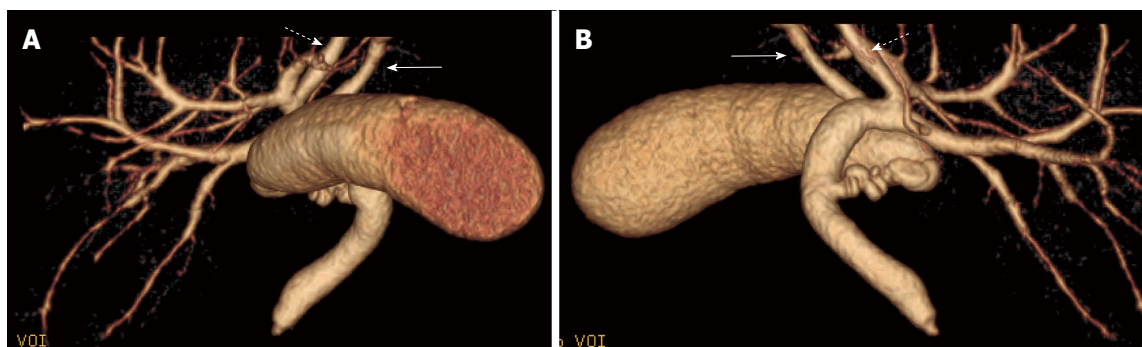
Drip infusion cholangiographic-computed tomography demonstrates that the cystic duct joins the extrahepatic bile duct on the right side and creates a hairpin turn anterior to the extrahepatic bile duct. One of two bile ducts of segment 2 (arrow) follows a route that is caudal to the umbilical portion of the left portal vein, that is, an infraportal course, and joins the extrahepatic bile duct; the other one (dotted arrow) follows a normal route, that is, a supraportal course. A: Computed tomography (CT) three-dimensional reconstruction, ventral view; B: CT three-dimensional reconstruction, dorsal view.
